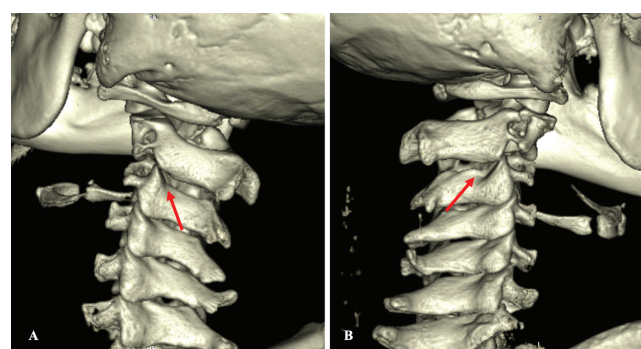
Cervical CT Scan 3D-reconstruction. Bilateral facet joints dislocation between C2 and C3 (arrow) left side (A) and right side (B).
